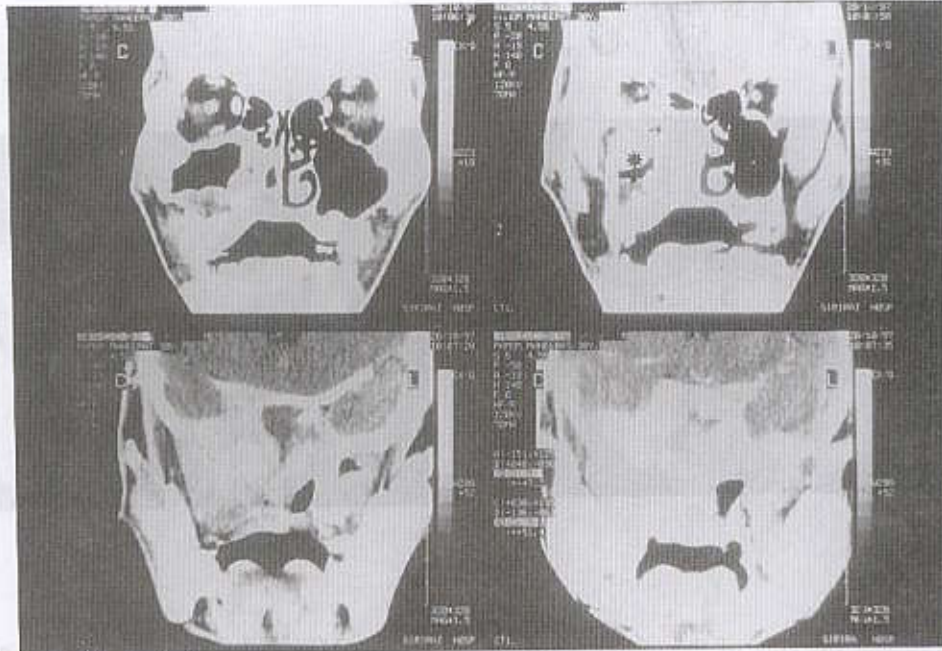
Coronal CT scan (stage T3) shows anterior extension of a CA nasopharynx into the right maxillary sinus.
